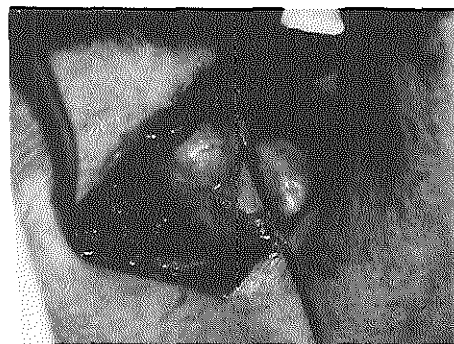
At surgery the ultrasound findings were confirmed (the connecting part of the laryngocele is in a vessel-loop).
